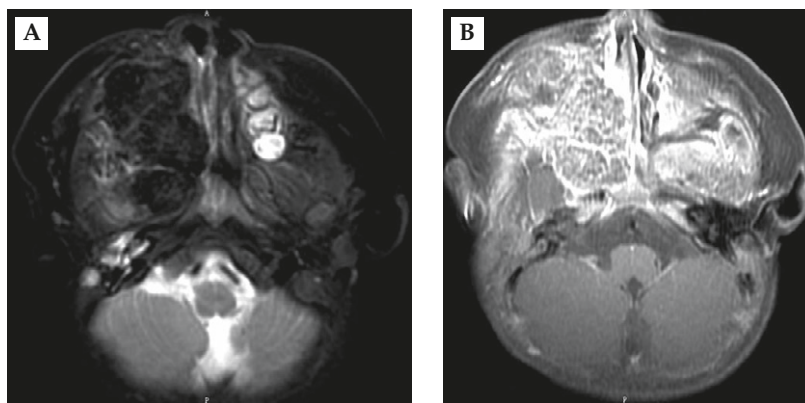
(A) Axial T2-weighted image demonstrating an extremely hypointense expansive mass in the right maxillary sinus. (B) Gadolinium-enhanced T1-weighted axial image demonstrating a peculiar reticular enhancing tumor without definite vascular structure within the mass.
